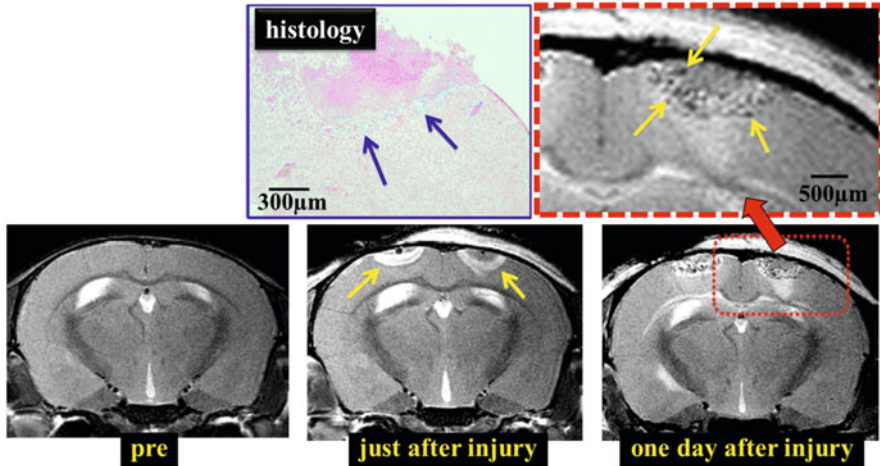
MRI image 1 day after injury shows the accumulation of labeled immune cells in and around the injured region
